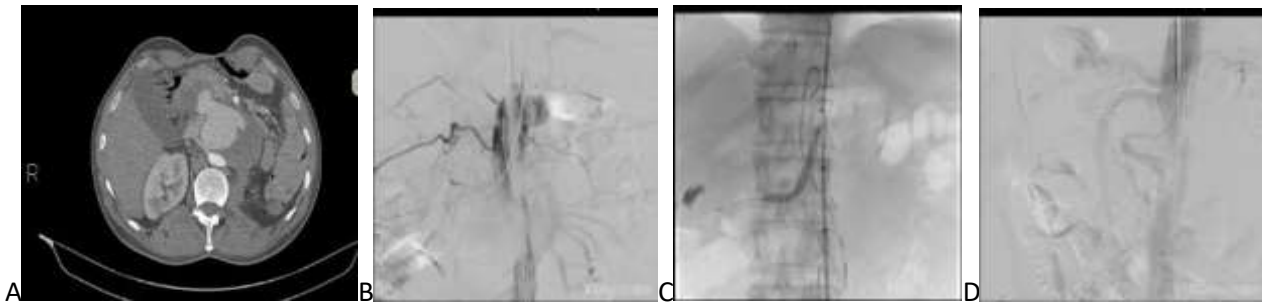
A 44-year-old patient with pseudoaneurysm of the aorta following nephrectomy after laparotomy due to a gunshot to the abdomen. (A) Contrast-enhanced computed tomography (CT) demonstrates abdominal aorta pseudoaneurysm. (B) Angiography shows active extravasation of contrast. (C) A 26 x 10 cm stent graft that fits the patient's aorta park in the aorta. Then, through the brachial sheet, a V12 stent graft 70 *56 mm was opened inside the renal opening and the end of the aorta stent was opened in the aorta and above the renal stent. (D). After the procedure was completed, no endoleak species were seen in the final angiography.
